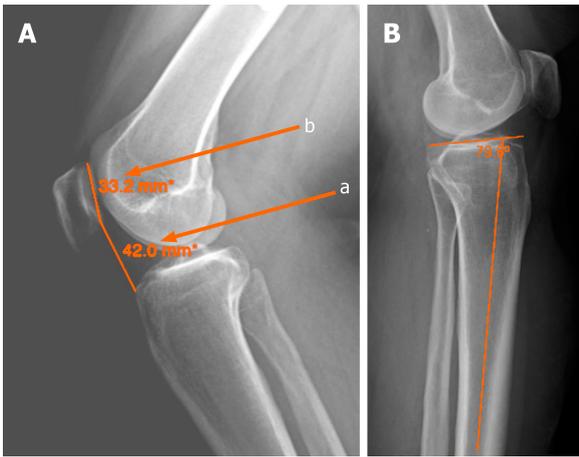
Knee X-ray images. A: Caton-Deschamps Index (a/b) for evaluation of the patella height; B: Posterior proximal tibial angle.
